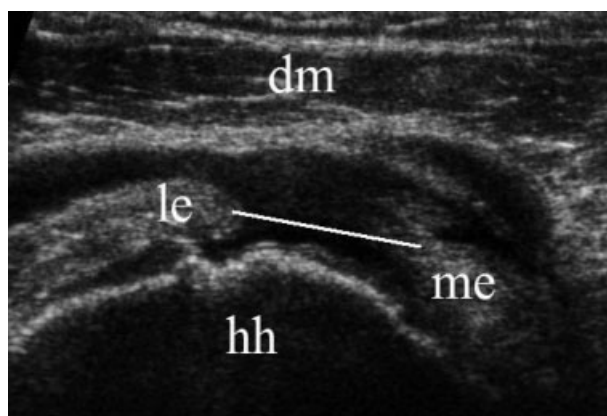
Lateral transverse sonogram shows a full-thickness tear of the rotator cuff. A measuring line is drawn between the edges of the tear. Abbreviations: dm, deltoid muscle; hh, humeral head; le, lateral edge of rotator cuff tear; me, medial edge of rotator cuff tear.
